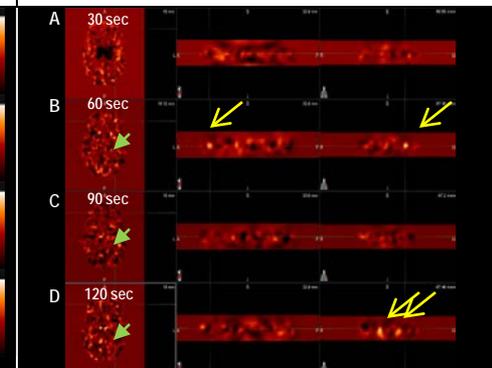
Dynamic SPECT. A slice is shown during each of 4 consecutive 30 sec epochs (A-D) taken as a ratio to the average of slices 3-19. Left depth electrode stimulation (green arrow; 30 sec duration) was initiated 60 sec after beginning the scanning session.
